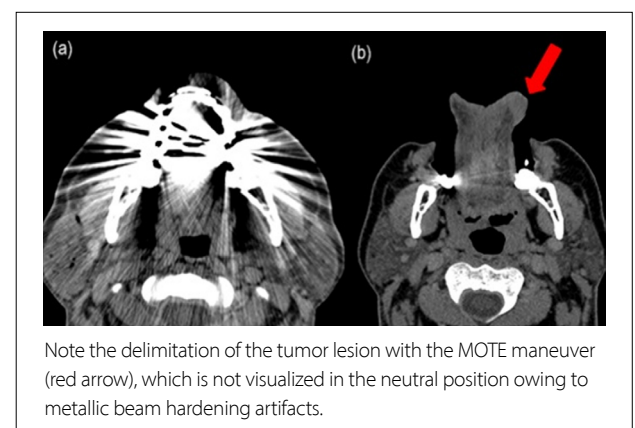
Contrast-enhanced CT in the axial plane in neutral position (a) and with MOTE maneuver (b).
